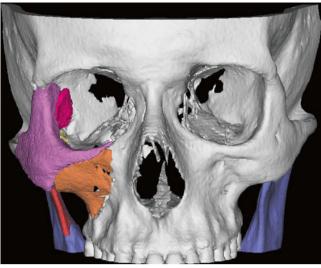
Reconstituted complex on CT, with reconstruction of lateral orbital floor and lateral wall
